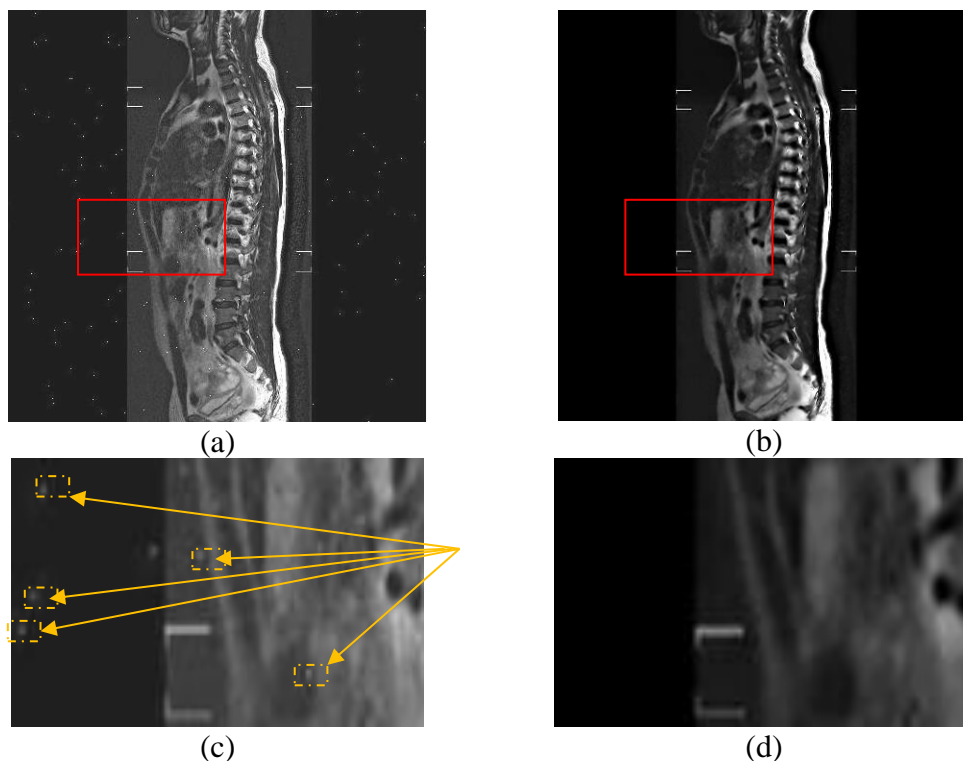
(a) Noisy MRI image. (b) After noisy removal [143]. (c) Cropped noisy image (red region in (a)). (d) Cropped de-noised image after (red region in (b)). The noisy points are marked with dashed yellow boxes in (c).
